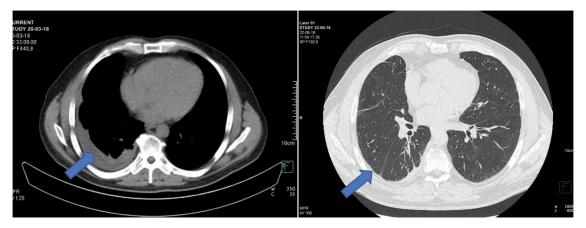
Images of chest CT. On left side: unilateral right-sided pleural effusion. On right side: CT after 4 months of follow-up: residual pleural effusion after glucocorticoid therapy.
